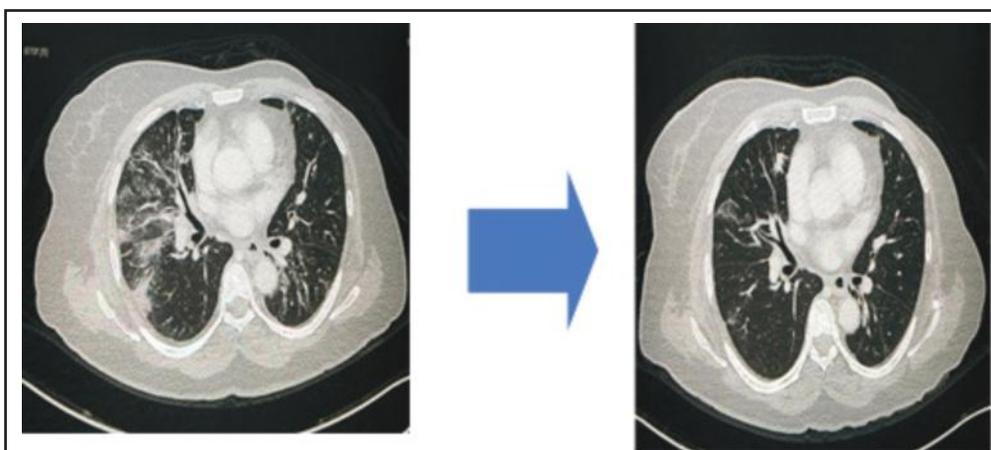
CT Thorax at baseline and 3 months after eribulin showing drastic response in the lung metastasis.
